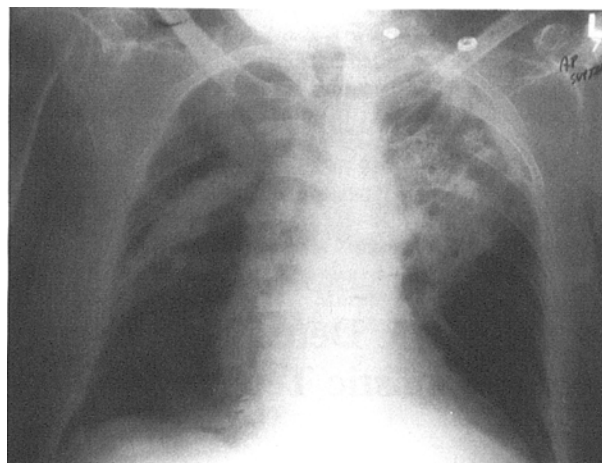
Case 1. Chest radiograph demonstrates bilateral lung infiltrates before removal of infected dentition.
